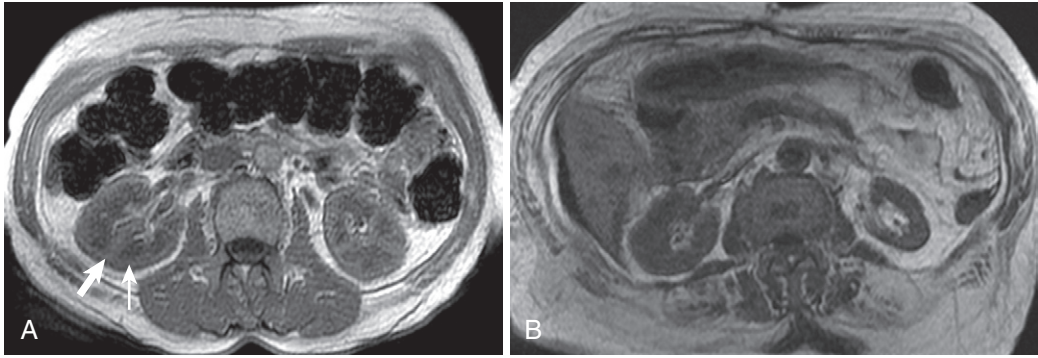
T1-weighted image of the kidneys shows corticomedullary differentiation. The axial in-phase image (A) in a patient with normal renal function shows greater contrast between the hypointense renal medulla (*thin arrow* in A) and relatively hyperintense renal cortex (*thick arrow* in A) compared with the axial in-phase image (B) in a patient with severely depressed renal function (glomerular filtration rate 14).
